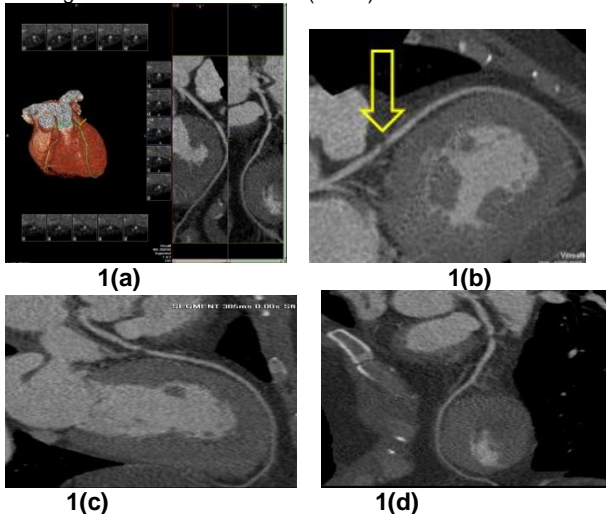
(a): Sagittal oblique reconstruction of CT coronary angiography in a 47 year old male with shortness of breath and chest pain. His calcium score was zero. CT coronary angiography confirmed a soft plaque in mid LAD causing severe luminal stenosis. (b) Magnified view of vessel showing true cross sectional view of the involved vessel. Note that the plaque is better visualized on the cross sectional view (multiple arrows pointing at the significant atherosclerotic plaque).
